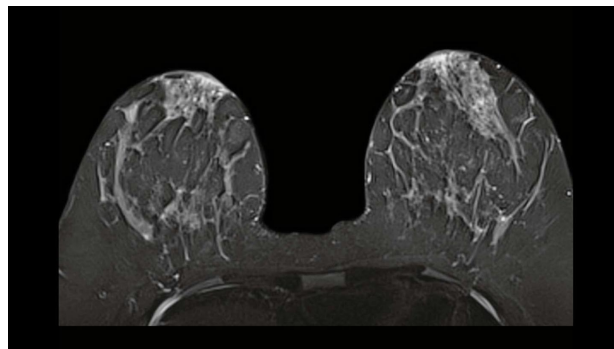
MRI scan of the breasts showing high-resolution cross-sectional imaging used to detect abnormalities in dense tissue.²²
